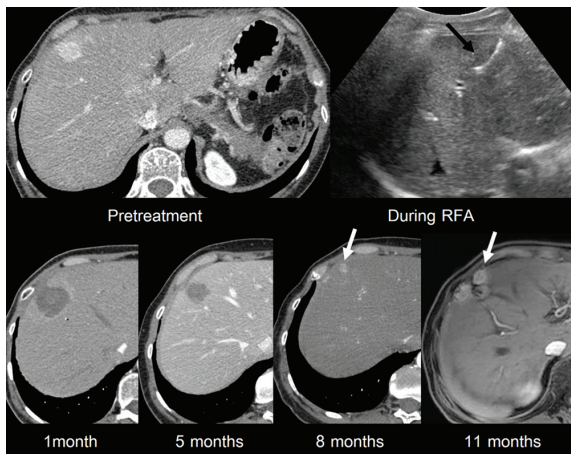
A 59-year-old woman with pancreatic neuroendocrine tumor with liver metastasis was treated by RFA (black arrow). CT scan at 1 and 5 months revealed complete tumor ablation with no residual or recurrent tumor. The follow-up images at 8 and 11 months showed local recurrent tumor adjacent to ablation zone (white arrow).
